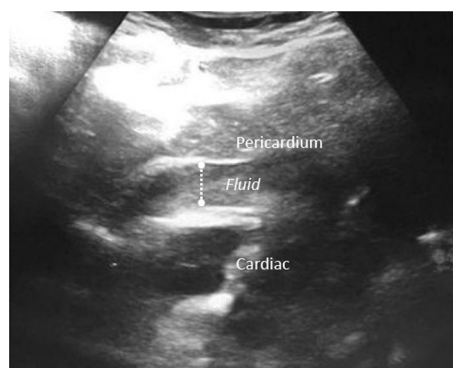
Cardiac ultrasound
